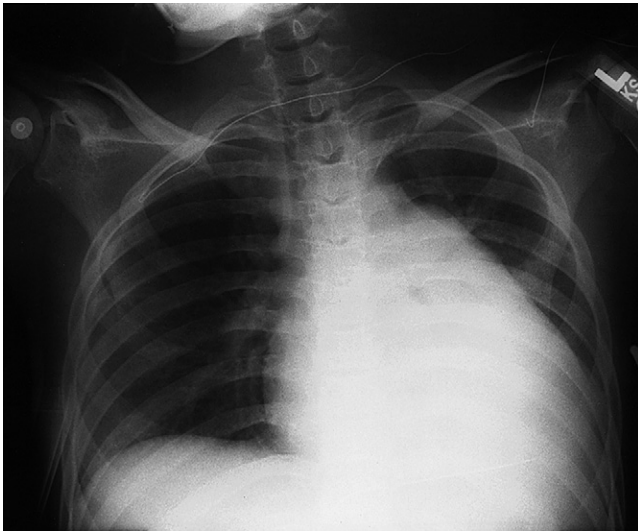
Portable chest radiograph of a 12-year-old female patient with scleroderma. The patient arrived at the ICU with sudden onset of orthopnea and thrombocytopenia. Cardiomegaly was observed. Echocardiography revealed pericardial effusion. However, pulmonary vascularity was normal in this patient. Physical examination revealed sclerodactyly. The patient eventually developed cor pulmonale as a result of pulmonary hypertension. Inflammatory changes suggestive of other collagen vascular diseases may be seen in the early course of scleroderma. Use of pulse intravenous methylprednisolone reduced these early inflammatory changes, although as an outpatient the patient maintained stable right-sided heart disease that was not responsive to immunosuppressive medication, consistent with scleroderma.
